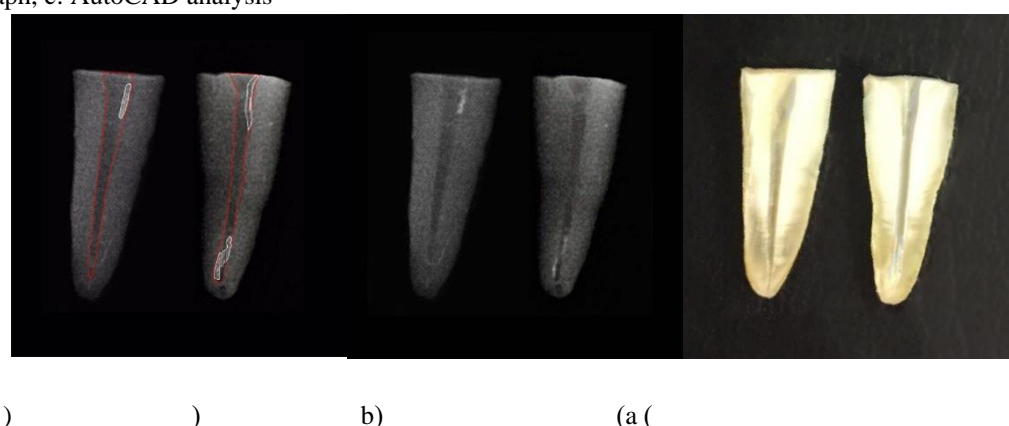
Longitudinal section of the halves filled with Endoseal MTA sealer after retreatment; a: photograph, b: digital periapical radiograph, c: AutoCAD analysis
